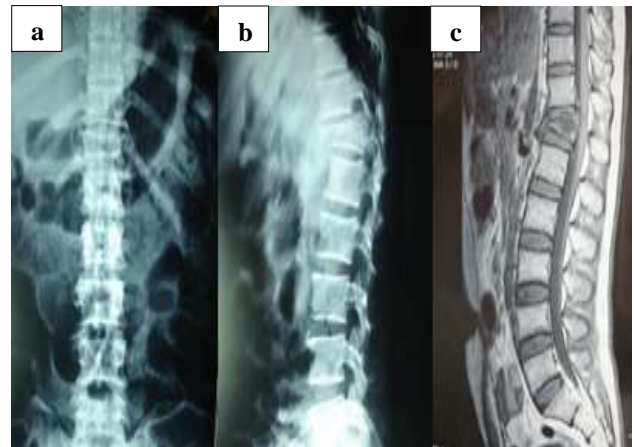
Case 1 (a) and (b) pre-operative x ray shows burst of D12, and (c) MRI shows burst of D12, compression of the cord.
